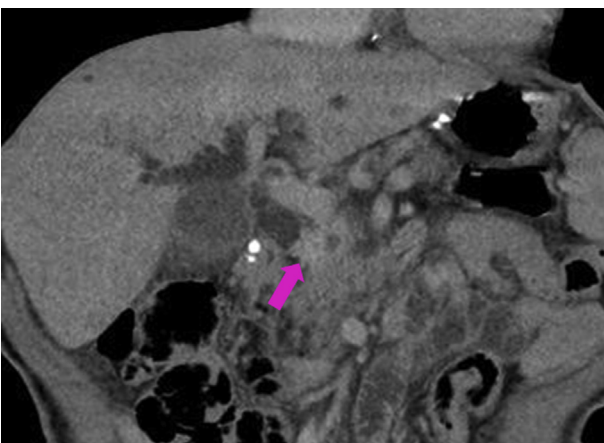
Contrast CT of the abdomen showing a mass with contrast effects in the distal bile duct (pink arrow).
